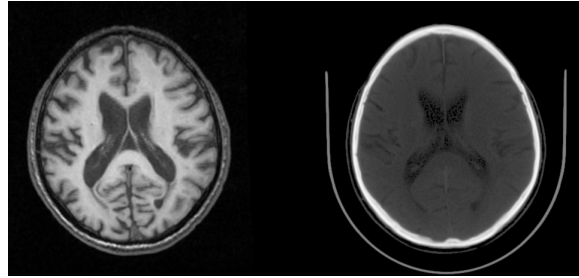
MRI – CT registration result.
